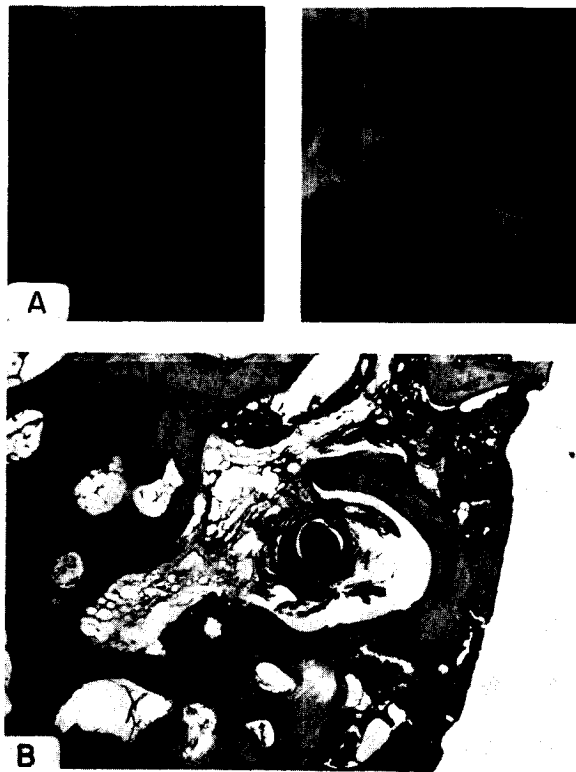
A. Radiograph of femoral head with extensive necrosis and segmental collapse in a 50-year-old alcoholic.
